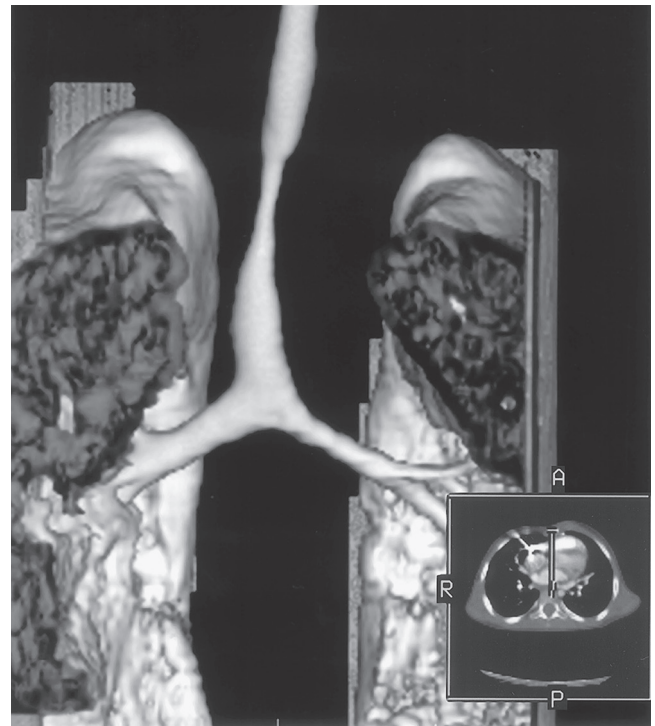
■ Computed tomography (CT) (inset) with three-dimensional reconstruction reveals a significant tracheal stenosis in the midportion of this child's trachea. The pathology at the time of surgery was essentially identical to the pathology indicated by the CT scan. A, Anterior; P, posterior; R, right.
